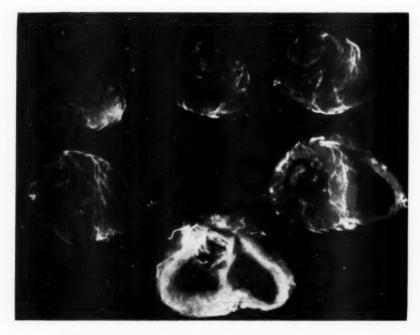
Roentgenogram of the injected heart in Case 143.
